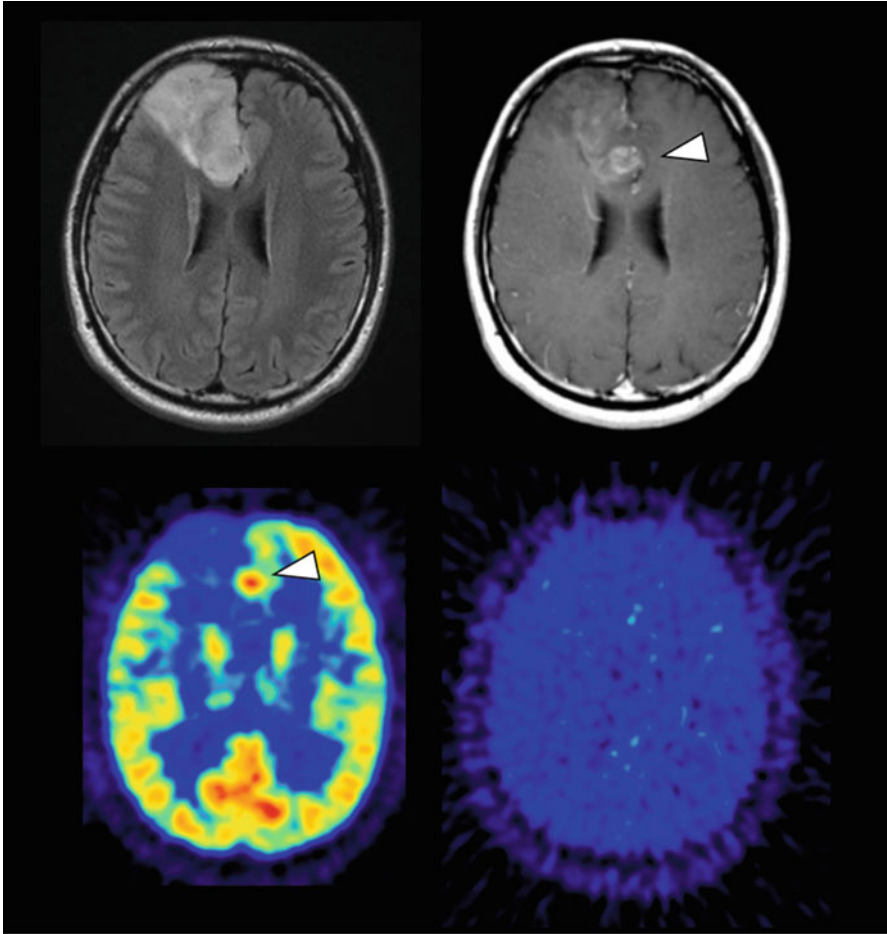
An anaplastic oligoastrocytoma case (grade III). (a) The FLAIR image showed a tumor in the right frontal lobe. (b) A small part of the tumor is enhanced after treatment with gadolinium contrast material (arrowhead). (c) The FDG uptake was observed in the enhanced part (arrowhead). The FDG uptake was higher than that in the left cerebral cortex. (d) No FMISO accumulated in the tumor
